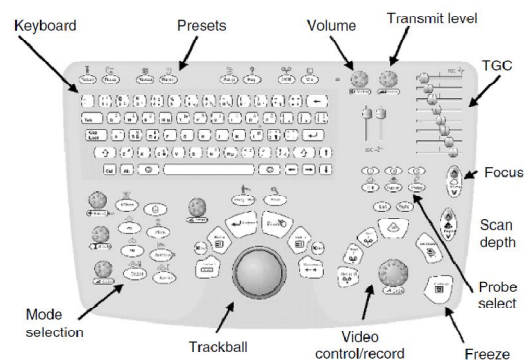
Keyboard of an ultrasound imaging system (courtesy of Philips Medical Systems) [27]
